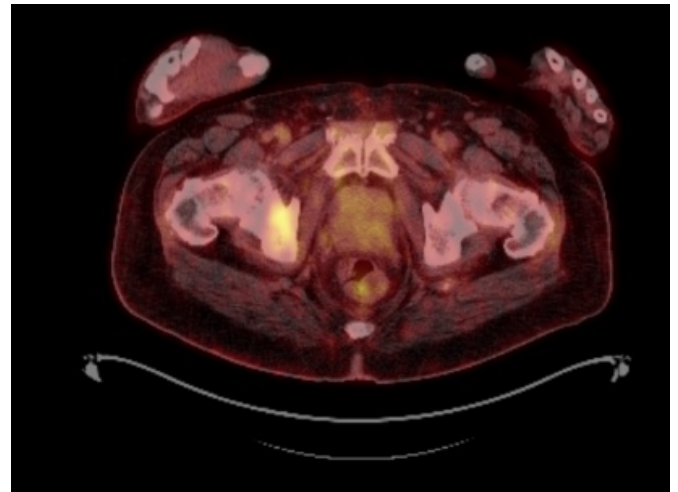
Sclerotic lesions with increased FDG uptake in the right iliac bone on PET-CT completed in January 2022.
